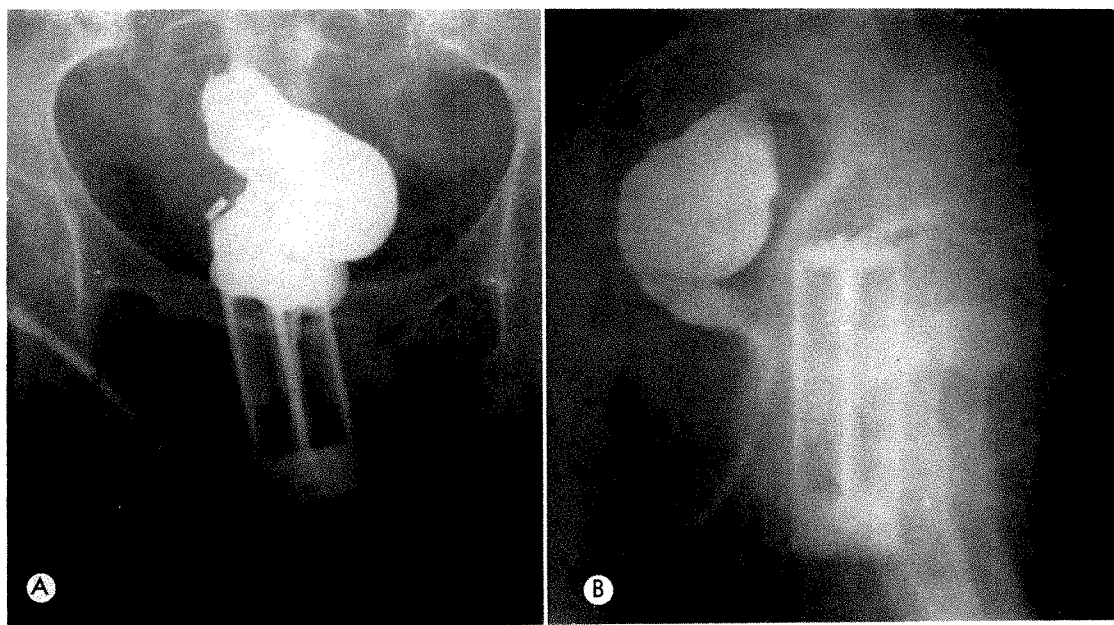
Typical (*A*) anteroposterior and (*B*) lateral pelvic roentgenograms.
